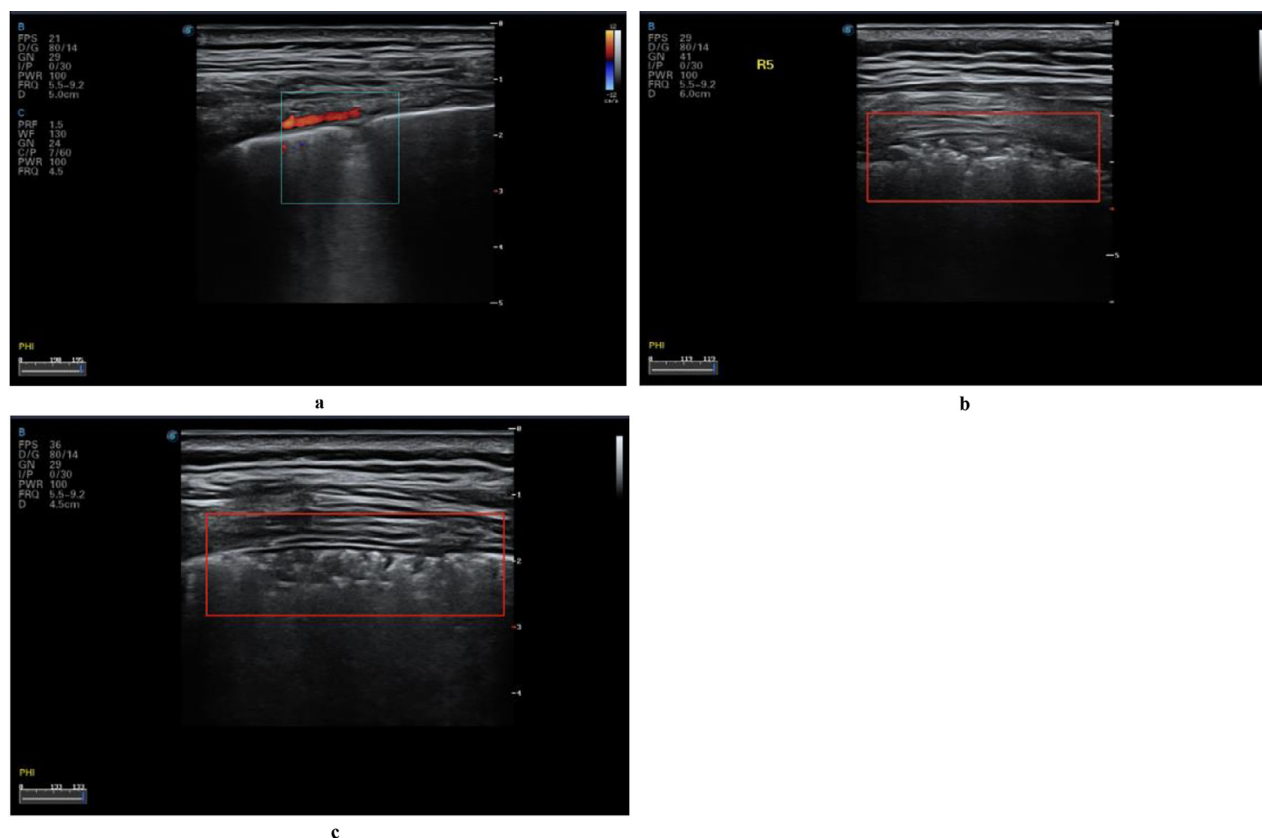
Lung ultrasound images acquired using a linear-array probe. (a) Interrupted pleural line and patchy consolidation in the left posterior lower area, with fixed B-lines. The origin point is round and dull, and the subpleural area thickened. Color Doppler flow imaging shows no blood flow signal. (b) The pleural line in the right posterior upper area is interrupted and disappears. There is an air bronchogram sign in the strip and faint consolidation, and the connecting surface of the lung tissues is rough and unsmooth, with B-lines. (c) Discontinuous pleural line in the right posterior lower area and strip consolidation and air bronchogram sign, with a large number of B-lines. Reprinted with permission from [Huang et al. \(2020\)](#).
